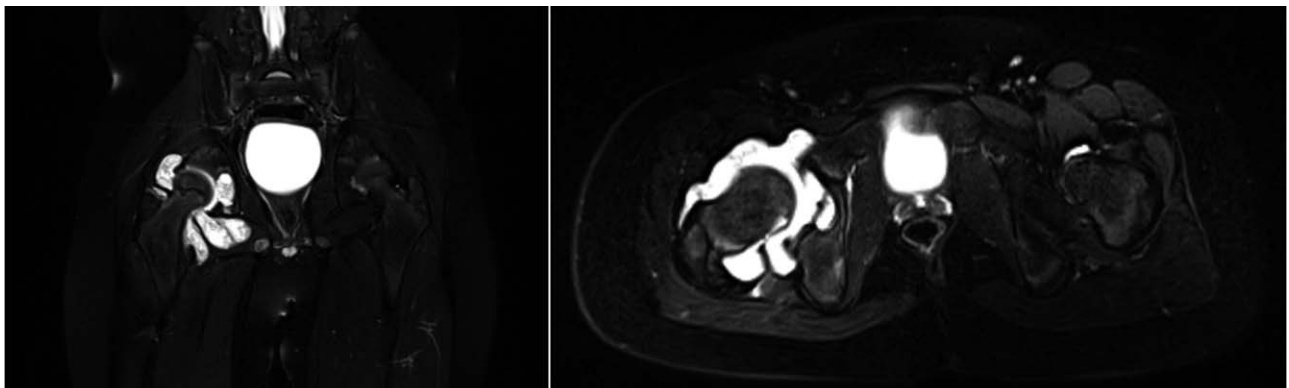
MRI showed a large amount of effusion in the right hip joint and abnormal signals. MRI = magnetic resonance imaging.
